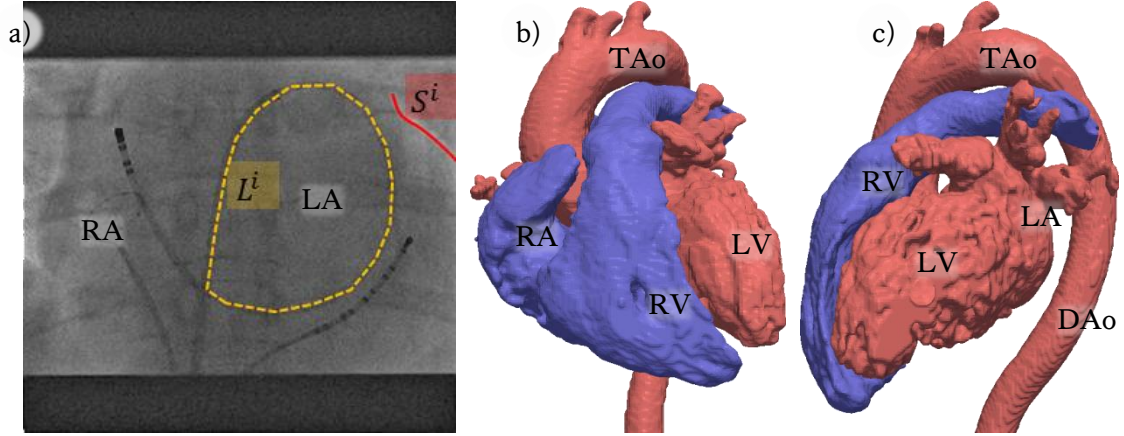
a) PA X-ray view of the patient's heart with a catheter inserted via the IVC and looped inside the LA. Both loop L^i and upper cardiac border S^i are manually segmented. Surface rendering of the heart obtained from MR image segmentation and triangulation is shown in b) AP and c) left lateral views. Different parts of the left (*light red*) and right (*light blue*) heart are labelled, including the transverse aorta (TAo).
